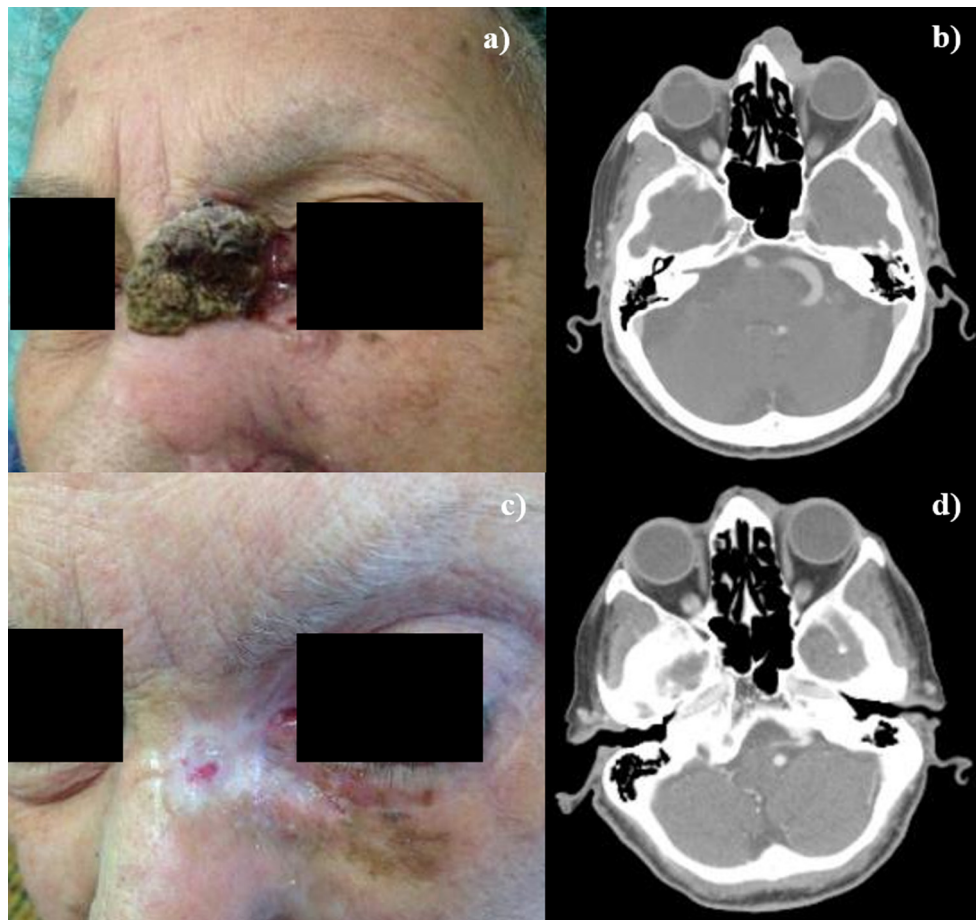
Basal cell carcinoma of nasal root and internal canthus of left eye. CT scan: the lesion involves the skin and the medial aspect of the orbit (a); Six weeks after ECT: the lesion disappeared with good healing of the skin (b); Six weeks after ECT: CT scan shows evident reduction of previous lesion (c).
